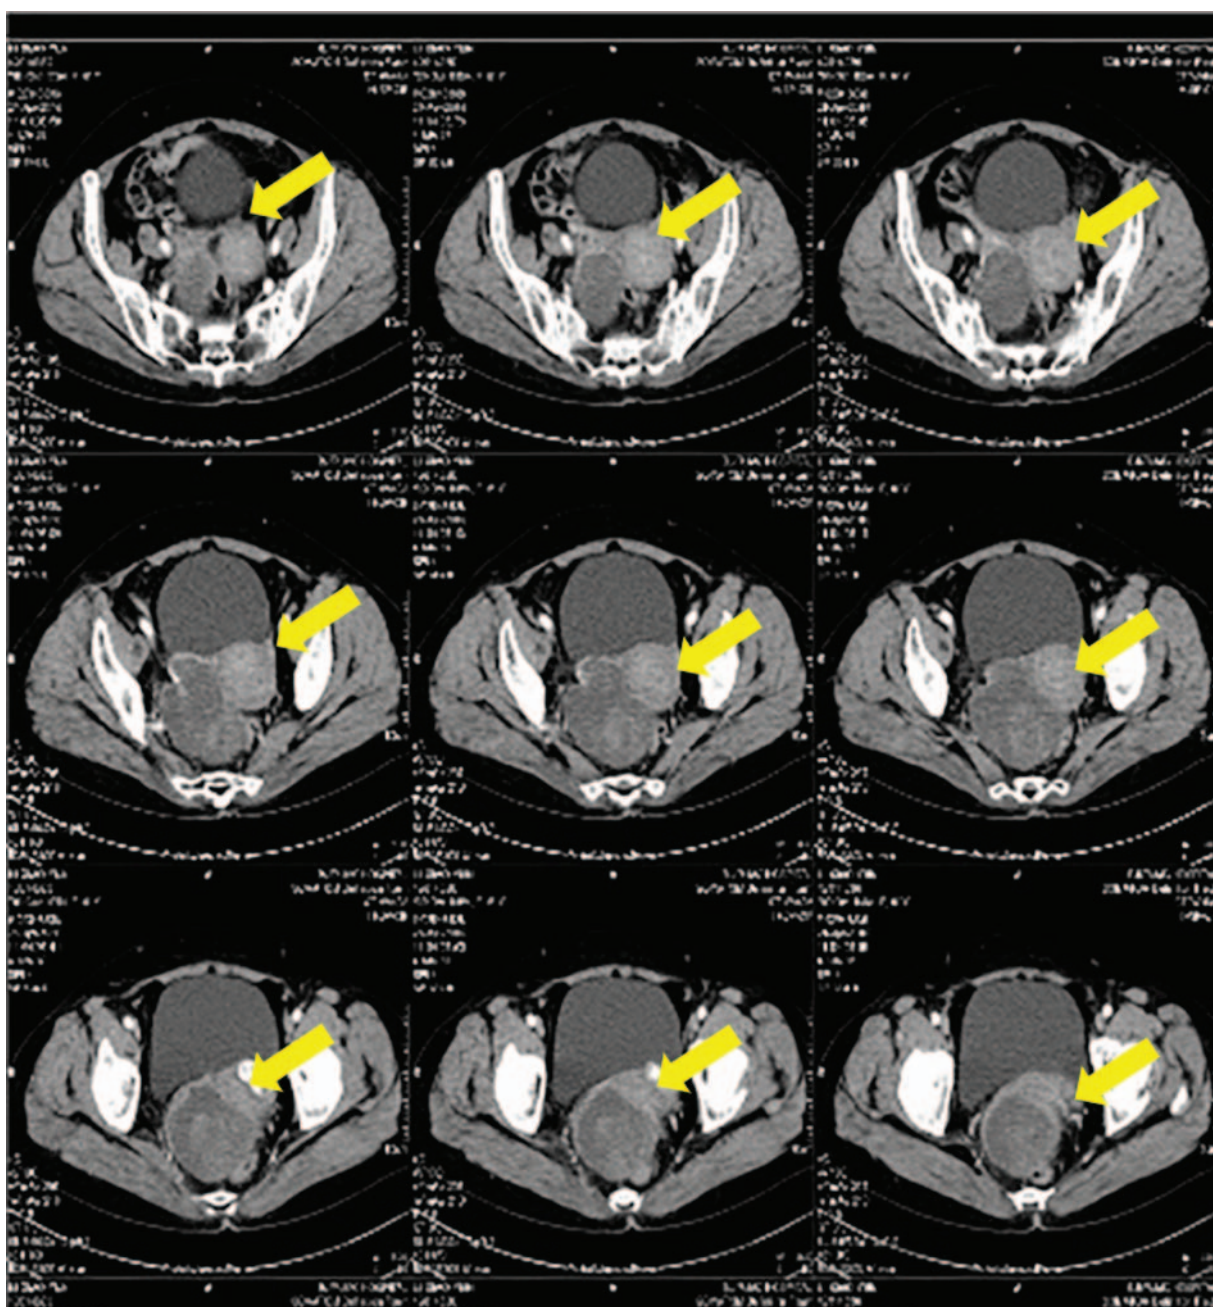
Case 1: Preoperative computed tomography images.
